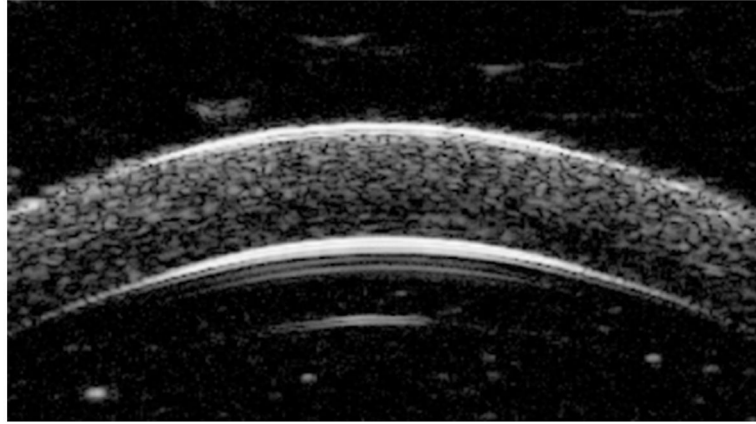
Ultrasound image reconstructed from the radiofrequency signal of a canine cornea after removal of epithelium shows sufficient speckle patterns throughout the entire cross-section.
